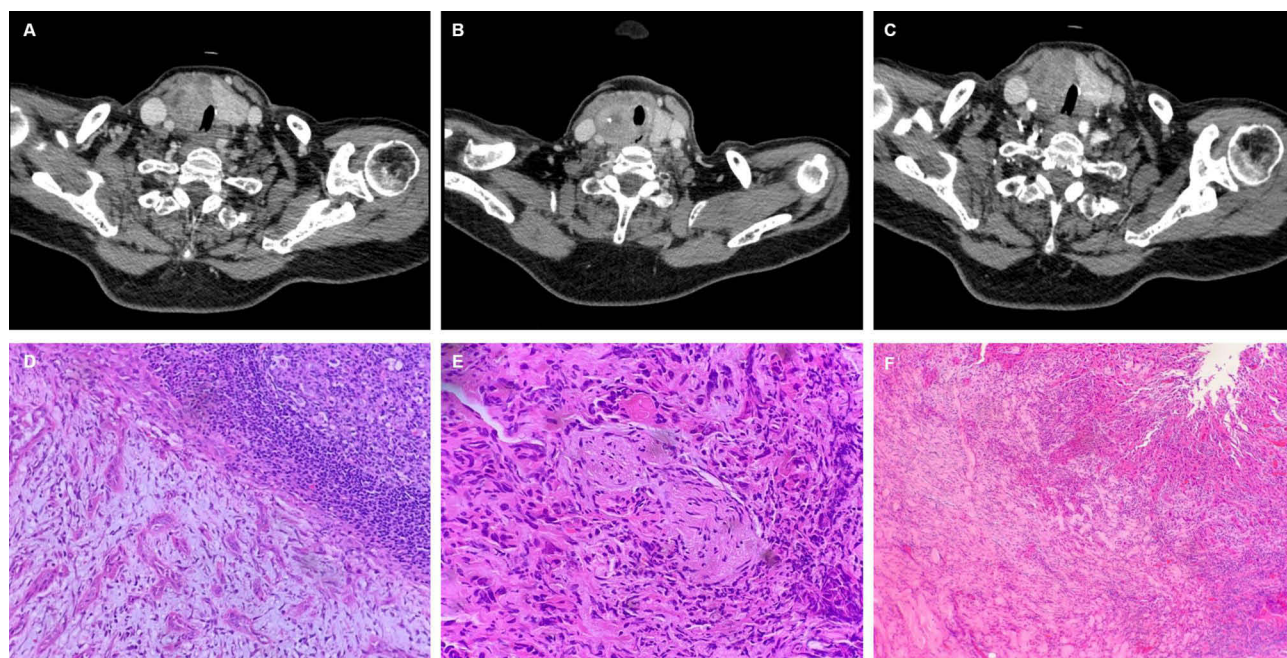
Representative pathological images of a case of ATC. (A) CT scan of the involvement of the trachea by ATC. (B) Intratumoral calcification and the involvement of the trachea by ATC. (C) CT scan of lymph node metastases in the carotid sheath. (D) Pathological image of cervical lymph node metastases (magnification=200×). (E) Pathological image of perineural invasion by ATC (magnification=400×). (F) Pathological image of skeletal muscle invasion by ATC (magnification=100×).
